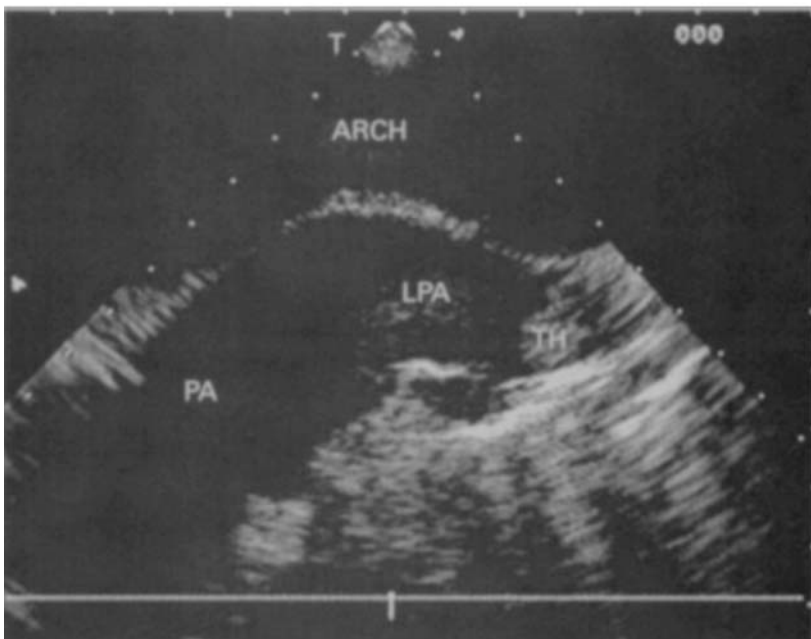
Transoesophageal echocardiogram showing thrombus in the left pulmonary artery (LPA). PA = pulmonary artery, TH = thrombus.
